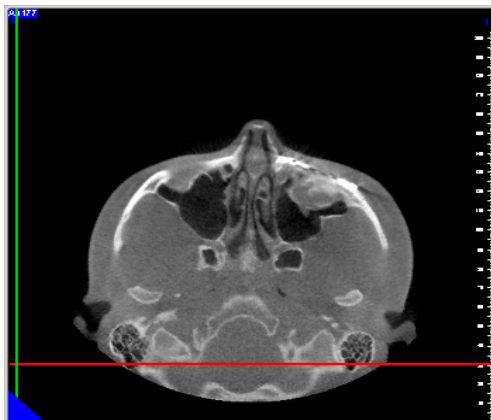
CBCT axial view from the raw data.
